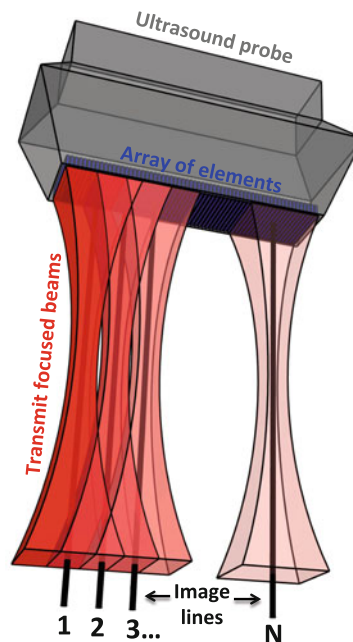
Sequential transmission of focused narrow beams as used in conventional cross-sectional (2D) ultrasound imaging. This 2D image would be made of N lines, N focused beams are then successively generated
